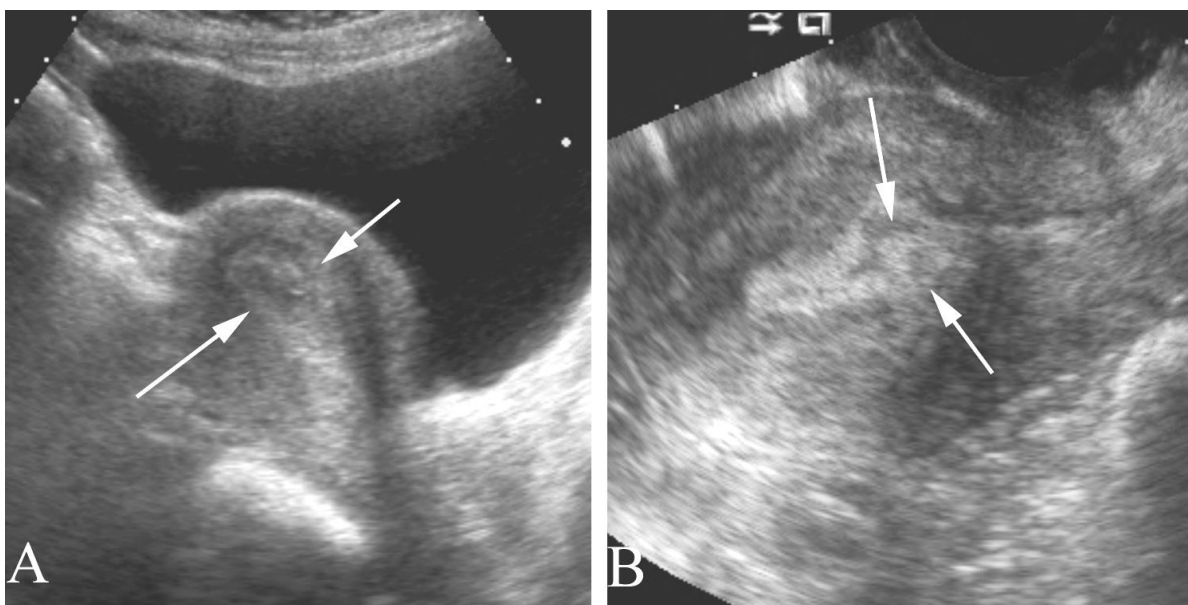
Endometrial polyp in a 50 year old with premenopausal bleeding. A. Transabdominal pelvic ultrasound study shows a diffusely abnormal thick endometrial stripe (arrows). B. Transvaginal pelvic ultrasound study demonstrates that there is a focal lesion along the mid to inferior aspect of the endometrial stripe. Biopsy demonstrated an endometrial polyp.
